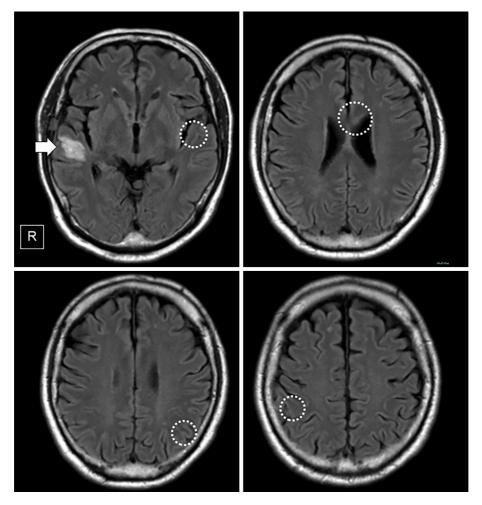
Brain magnetic resonance imaging on day 27 of admission. Fluid-attenuated inversion recovery imaging indicates a reduction in the size of the right temporal lesion (arrow) and complete disappearance of the other previously observed white matter lesions (dashed circles).
